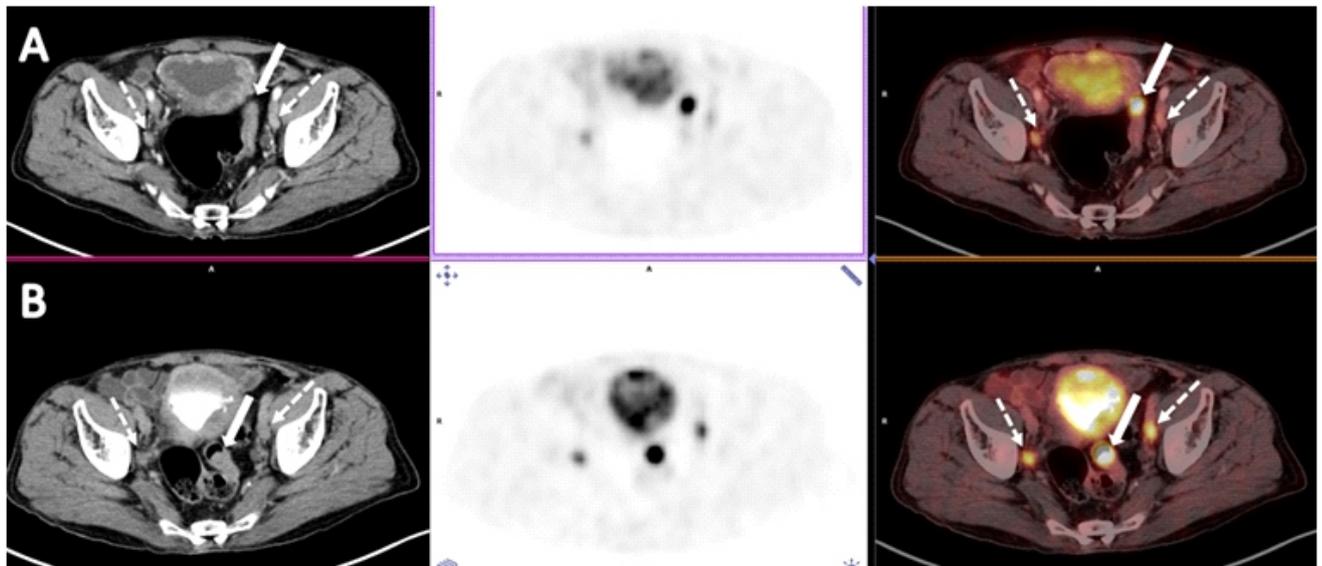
A 71-years-old man who had a bladder tumor underwent PET/CT. In the first hour (early) images (A: CT, PET, Fusion images), the increased ¹⁸F-FDG uptake (SUVmax: 11) observed in the bladder walls became prominent in the second hour (late) images (B: CT, PET, Fusion images) (SUVmax: 15.7) and the tumor invades the rectum and prostate gland (not shown). In the late images (B) of the lymph nodes observed in the bilateral parailiac area (dashed arrows), a significant increase in ¹⁸F-FDG uptake is observed, and the early-late SUVmax values were 4.36 and 11.1, respectively. Intense ¹⁸F-FDG uptake (SUVmax: 16.8) is observed in early and late images in the sigmoid colon (arrows). The pathological examination showed pT2a adenocarcinoma for colon and pT4N2 invasive urothelial carcinoma for bladder.
